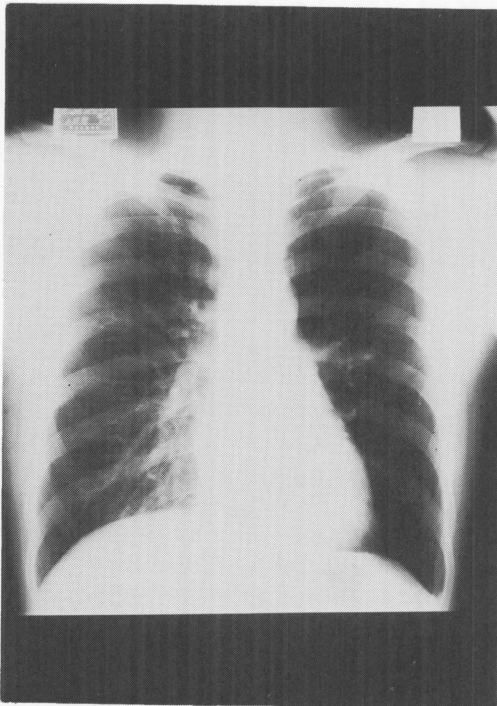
Plain chest roentgenography showed unilateral hyperlucency of the left lung with small pulmonary artery and its branches.
